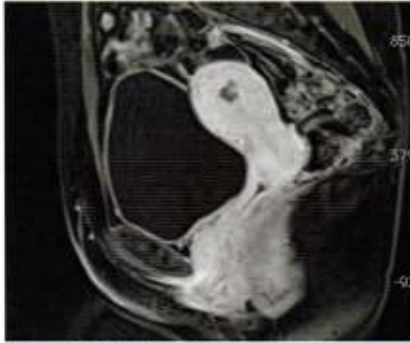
MRI at 8 months postembolization.
